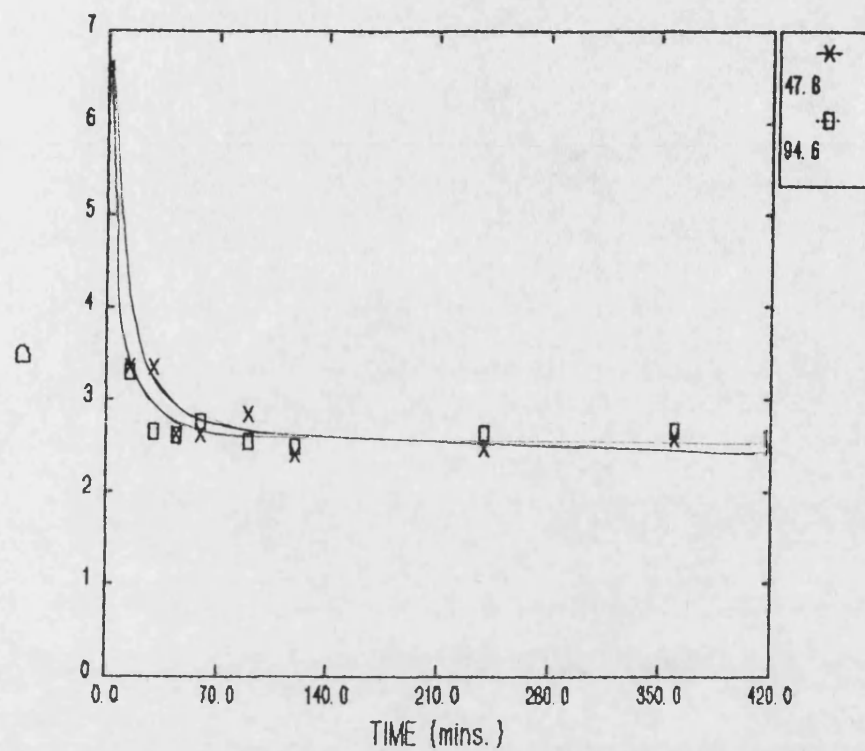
Effect of varying ultrasonic intensity on the molecular weight distribution for a 0.5% (w/v) solution
